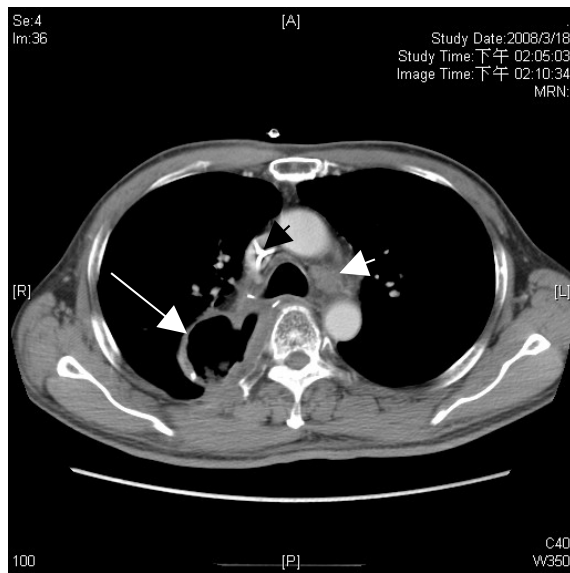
Chest CT, Post-operation:
